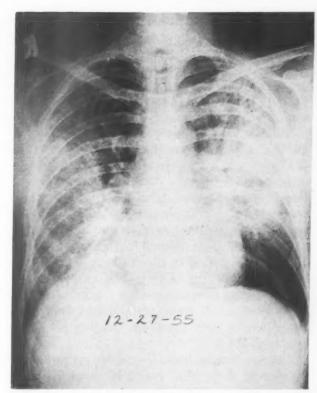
Case II. Roentgenogram of chest taken during final hospital admission (December 27, 1955) demonstrating extensive bilateral shadows attributed to uremia.
